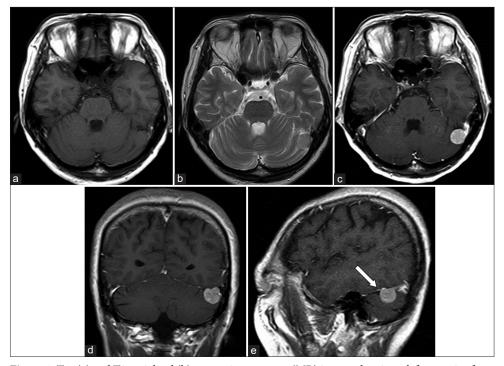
T1- (a) and T2-weighted (b) magnetic resonance (MR) images showing a left posterior fossa meningioma (1.6 cm \times 1.6 cm \times 1.7 cm). Gadolinium-enhanced axial (c), coronal (d), and sagittal (e) images showing a well-enhanced mass. The dural tail sign is seen in the sagittal image (arrow).
